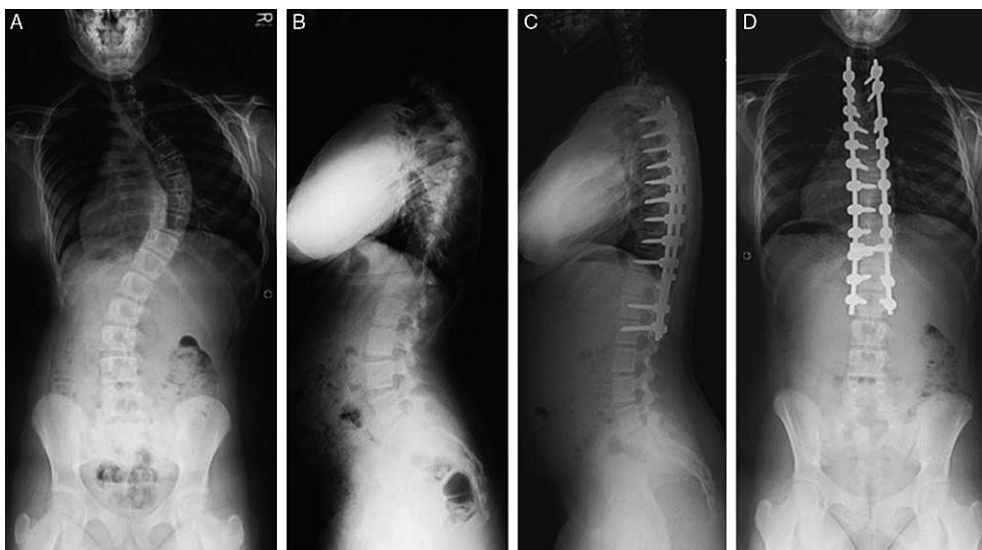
A–D, preoperative spine X-rays of a patient with screw instrumentation
